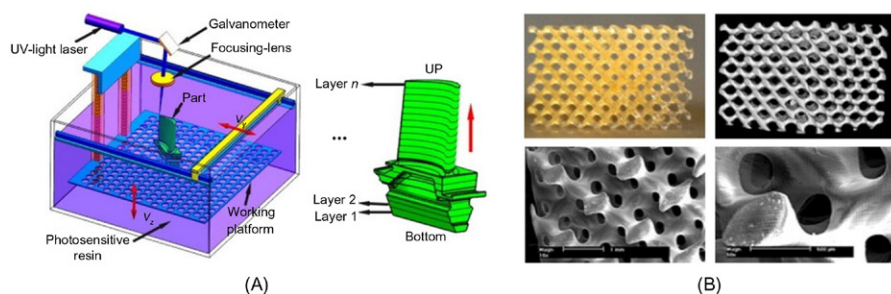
(A) Scheme of the stereolithographic (SLA) apparatus; (B) photograph, μ CT, and SEM images of a poly(ϵ -caprolactone)-based tissue engineering scaffold built by stereolithography using 1500 m macromer.
